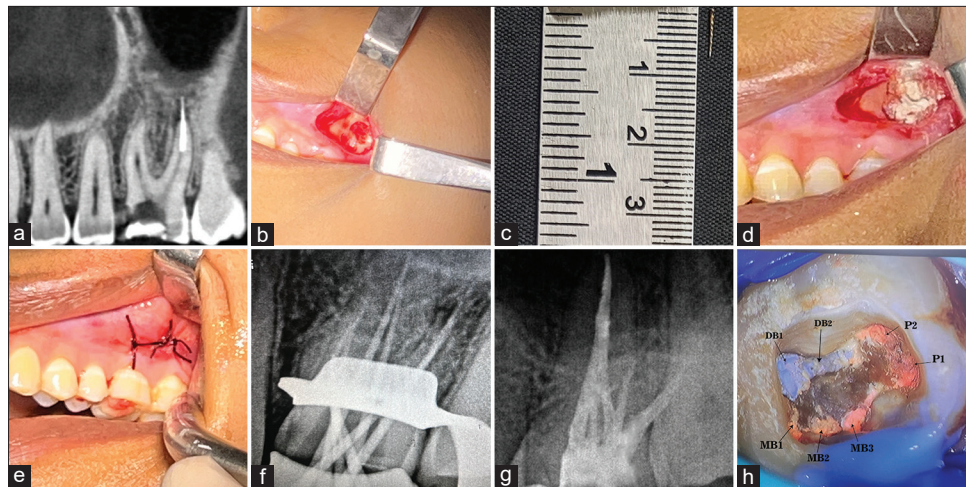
(a) The axial section of the cone beam computed tomography, with the large field of view, flat panel detector (17 mm × 13.5 mm cm in size) operating at 90 kv and 6 mA, showing the fractured instrument beyond the apex. (b) The intraoral image showing a 2–3 mm window created at the anterior wall of the sinus and the broken instrument was identified in the periapical region of 26 after the flap was retracted using Austin's retractor, (c) The image is showing the file of size 6.7 mm was removed using mosquito forceps. (d) The intraoral image showing the area was sealed with MTA (Angelus, Londrina-PR-Brazil). (e) The intraoral image showing the wound was properly closed with the single interrupted suturing technique using 3-0 vicryl sutures. (f) The intraoral preoperative periapical radiograph showing the master cone assessment with the accessory gutta-percha cones. (g) The intraoral preoperative periapical radiograph showing obturation was performed using an AH Plus sealer (Dentsply Sirona, Charlotte, USA) with an equivalent size of gutta-percha cones (Dentsply Sirona, Charlotte, USA). (h) The intraoral image showing the obturation that was performed using an AH Plus sealer (Dentsply Sirona, Charlotte, USA) with an equivalent size of gutta-percha cones (Dentsply Sirona, Charlotte, USA)
